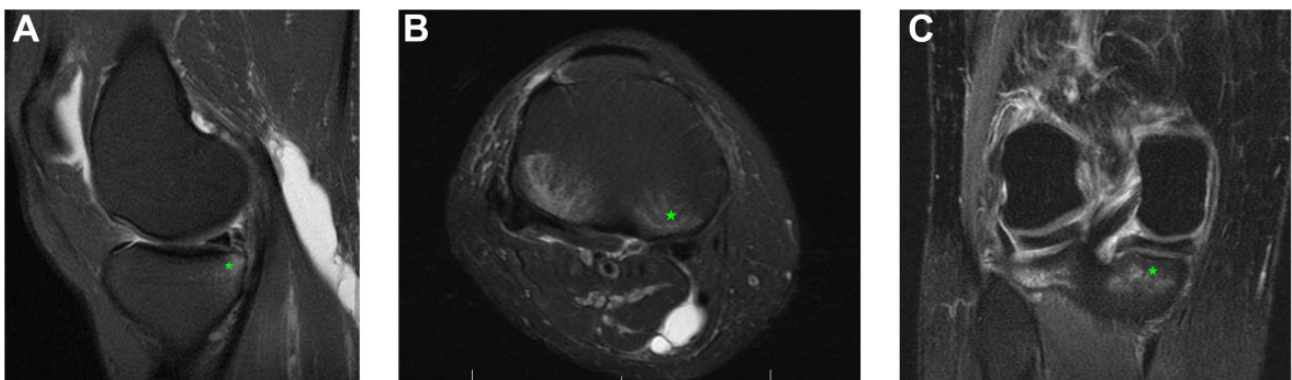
(A) Sagittal, (B) axial, and (C) coronal T2 magnetic resonance imaging sequences after an anterior cruciate ligament injury. Edema of the posterior medial tibial plateau (green star) is evident in all 3 planes.
